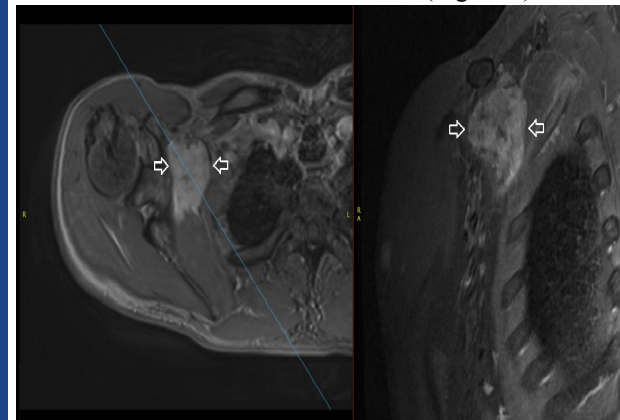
5.3 x 3.8 x 5.6 cm enhancing soft tissue mass medial and contiguous with the scapula and coracoid process on T1 weighted axial (right) and coronal (left) chest imaging post contrast on Siemens 3 Tesla MRI
